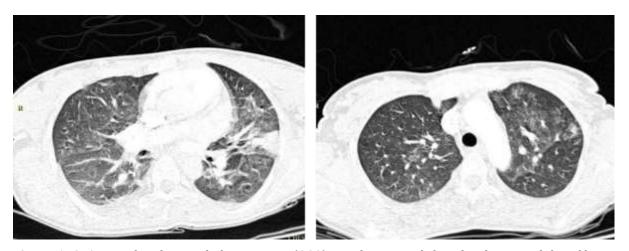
CTA; Peripheral ground glass opacity (GGO) mostly seen at left and right upper lobe of lungs and consolidation with subsegmental collapse at anterior segment of the left lower lobe suggestive of COVID-19 infection
